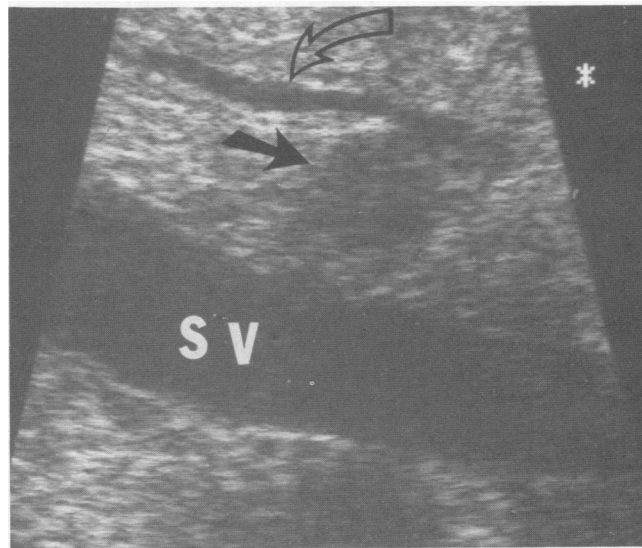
Intraoperative sonogram showing a 0.8 cm discrete hypoechoic lesion (black arrow) within the pancreas between the main pancreatic duct (open arrow) and splenic vein (SV). (From Gorman B, Charbonneau JW, James ME, et al: *Benign pancreatic insulinoma: Preoperative and intraoperative sonographic localization*. *AJR* 1986; 147:929.)
